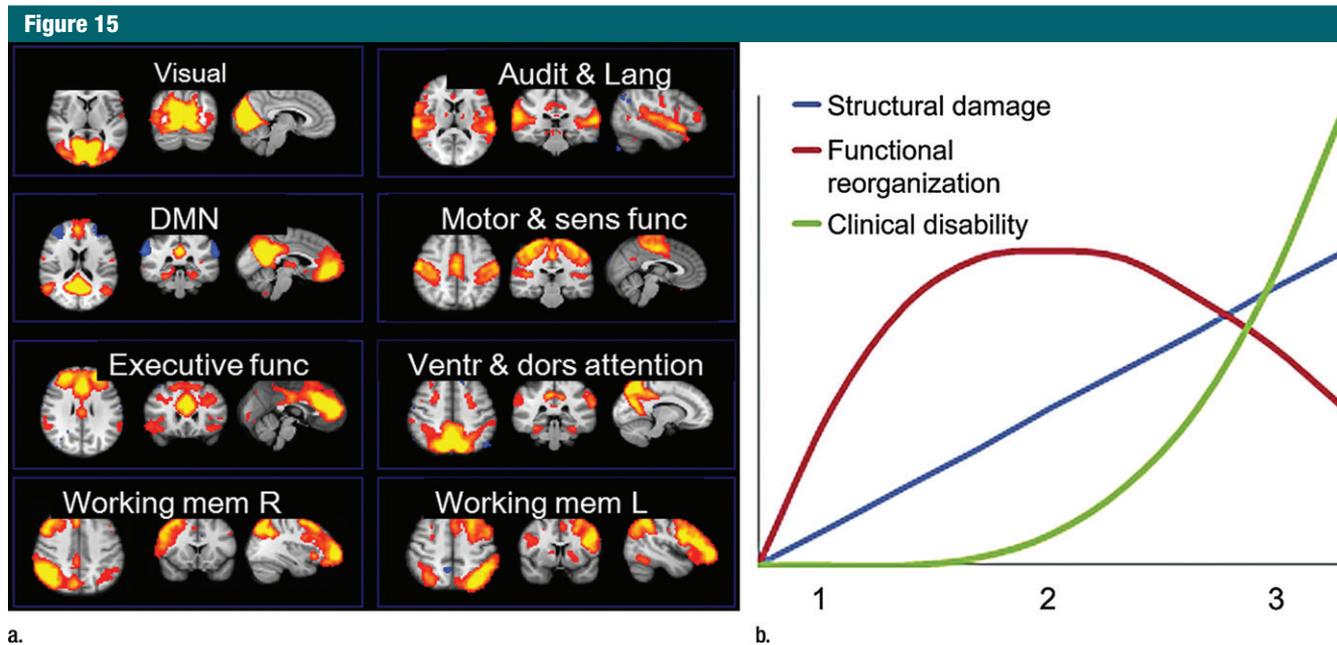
Early compensatory RS functional MR imaging activity in multiple sclerosis. (a) In six of eight networks identified using independent component analysis, increased synchronization was found in patients with a clinically isolated syndrome compared with healthy control subjects or patients with more advanced relapsing-remitting disease. (Reprinted, with permission, from reference 168.) (b) It is hypothesized that subclinical damage in early disease is compensated for by increased functional activity and that clinical impairment only becomes obvious when compensatory mechanisms are exhausted. (Reprinted, with permission, from reference 166.)
